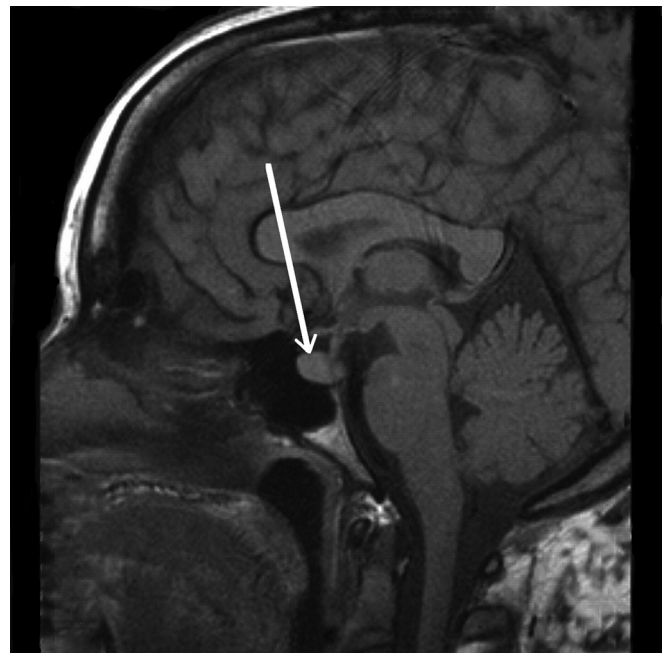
Magnetic Resonance Imaging (MRI) of the brain revealed the loss of posterior pituitary bright spot, suggesting the diagnosis of central diabetes insipidus.
